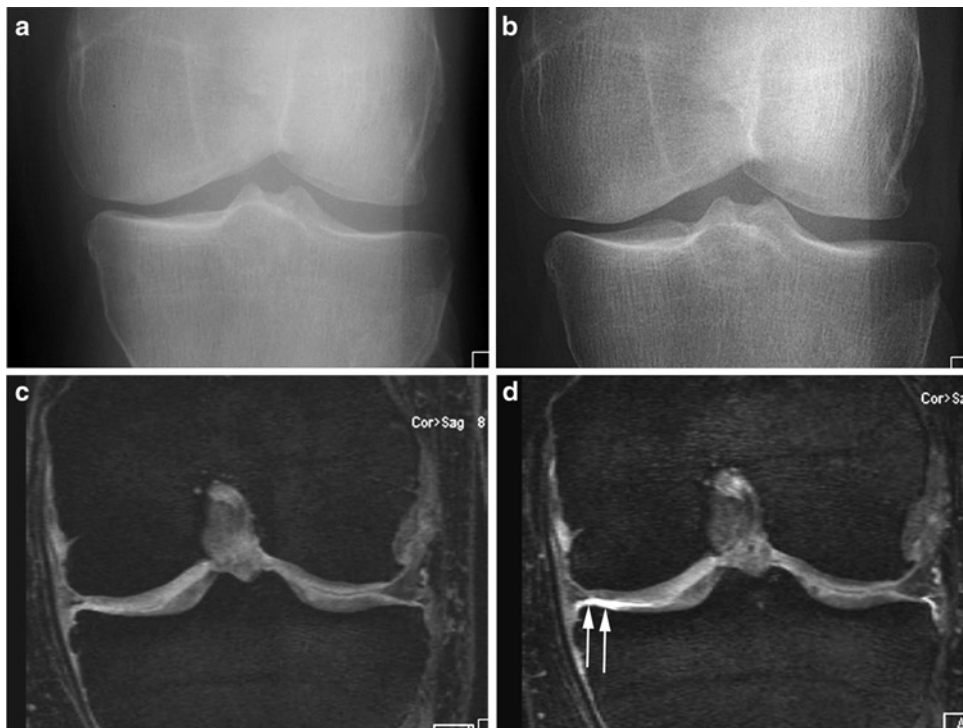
Focal cartilage loss on MRI. Radiography does not show progressive joint space narrowing (JSN) (a, b), i.e., identical joint space width from baseline to follow-up. Coronal DESS MRI (c, d) shows
